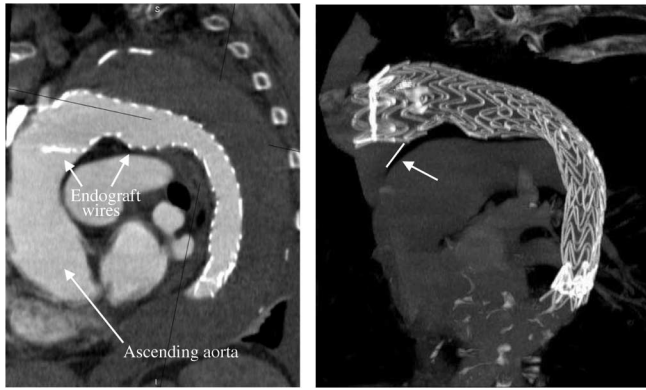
2-D section (left) and maximum intensity projection (right) of a 3-D CTA dataset of a patient with clinic type B dissection after implantation of an EVG into the aortic arch beginning distal to the left common carotid artery. The EVG shows a significant misalignment with respect to the inner contour of the proximal aortic arch (see the arrow on the right).
